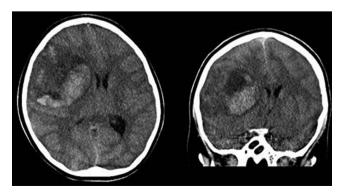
Preoperative head CT demonstrating a large right frontal lobar heterogeneous haemorrhage with acute and subacute components without oedema, an 8 mm midline shift and uncal herniation (right).
